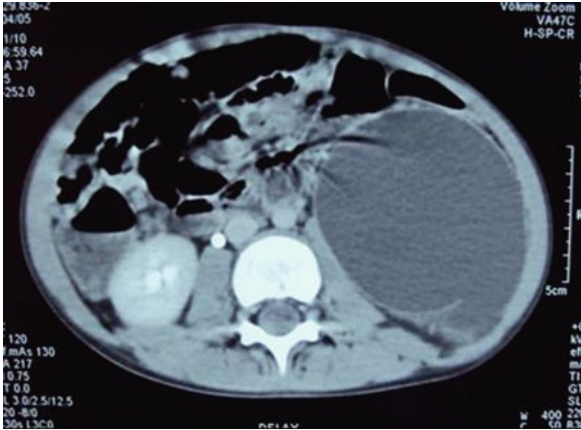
Abdominal CT from same boy showing mass with no renal tissue observed: diagnosis of Right PUJ obstruction.
